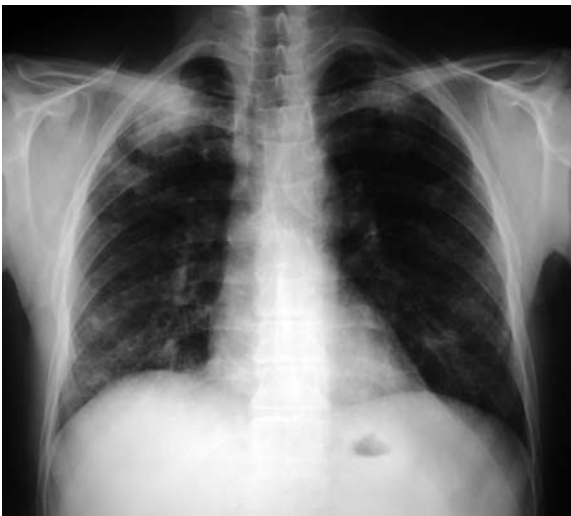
Coal worker's pneumoconiosis: three postero–anterior chest radiographs obtained at 7-year intervals in a coal miner showing increasing profusion of small round opacities
